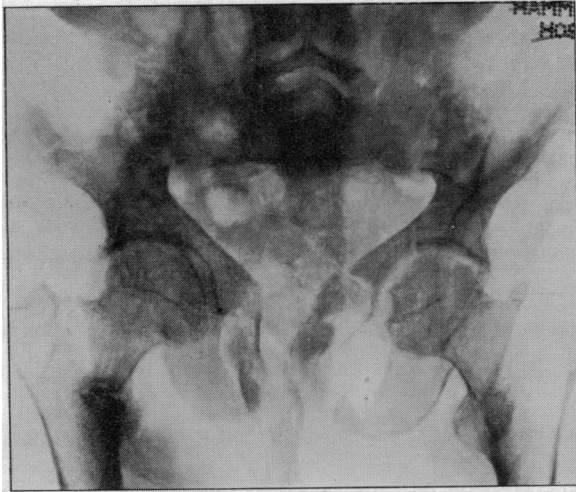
X-ray on admission showing tri-radiate pelvis, Milkman fractures of right femur and right ilium and fractures in the pubic rami.
